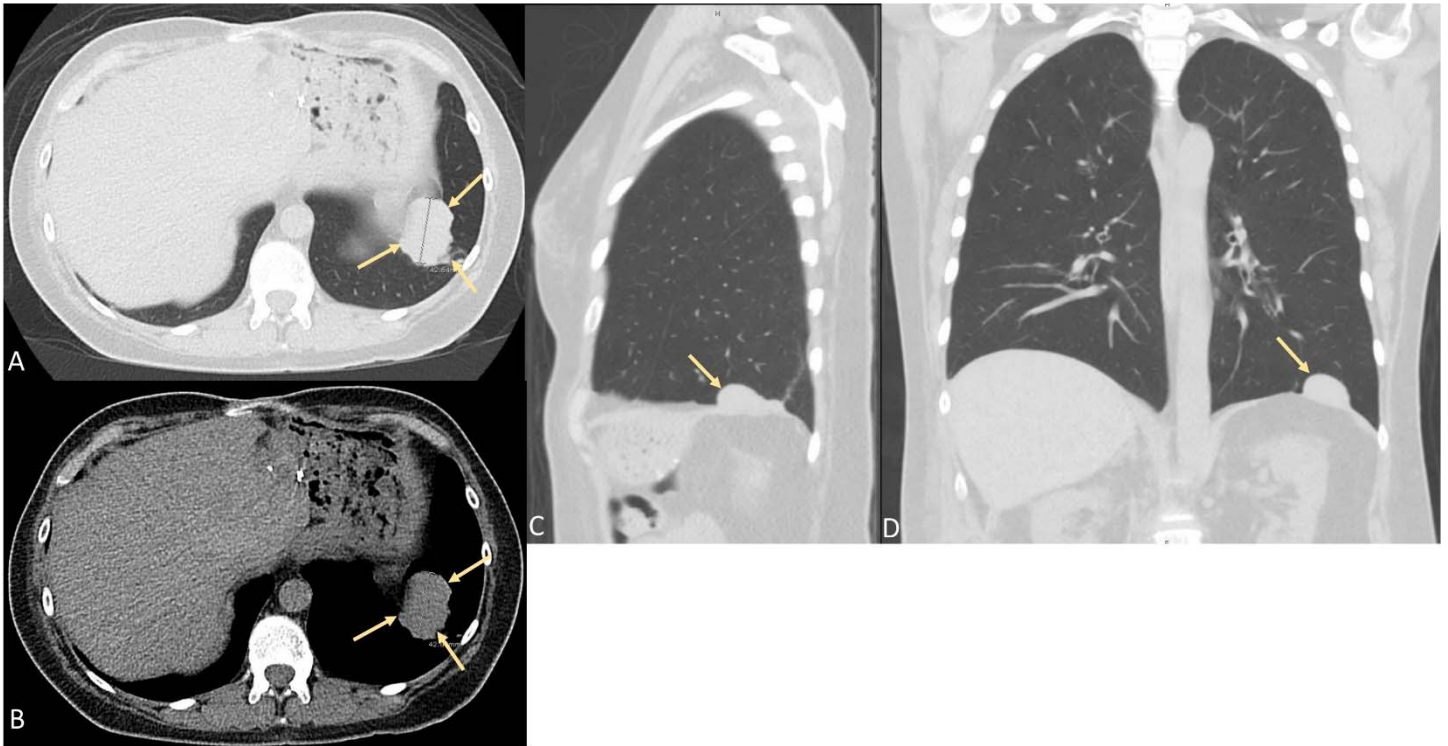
Non-contrast CT chest reformatted in the axial (A, B), sagittal (C), and coronal (D) projections showing a intrathoracic soft tissue mass abutting the left hemidiaphragm (yellow arrows).
